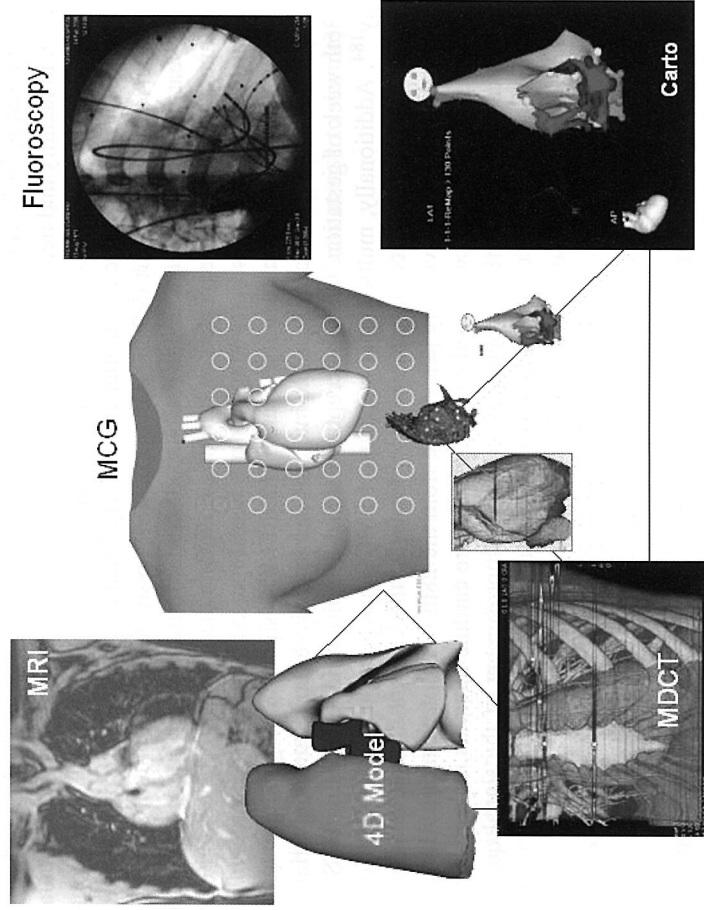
Future imaging for interventional electrophysiology is foreseen as the multimodal integration between preinterventional MCG-based electro-anatomical imaging into patient's 4D model of beating heart in a breathing chest obtained with cardiac magnetic resonance imaging (MRI) and interventional fluoroscopic and non-fluoroscopic catheter navigation [modified from R. Fenici, D. Brisinda, *The Anatolian Journal of Cardiology* 7 (Suppl. 1) (2007) 23].
